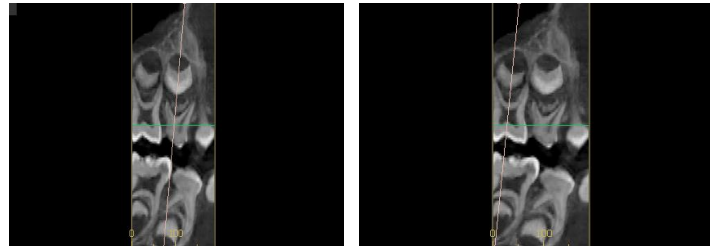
Panoramic reconstruction of maxillary right 1st primary molar (A) and right 2nd primary molar (B) arc CBCT. Cursor following long axis of the tooth (pink line).
